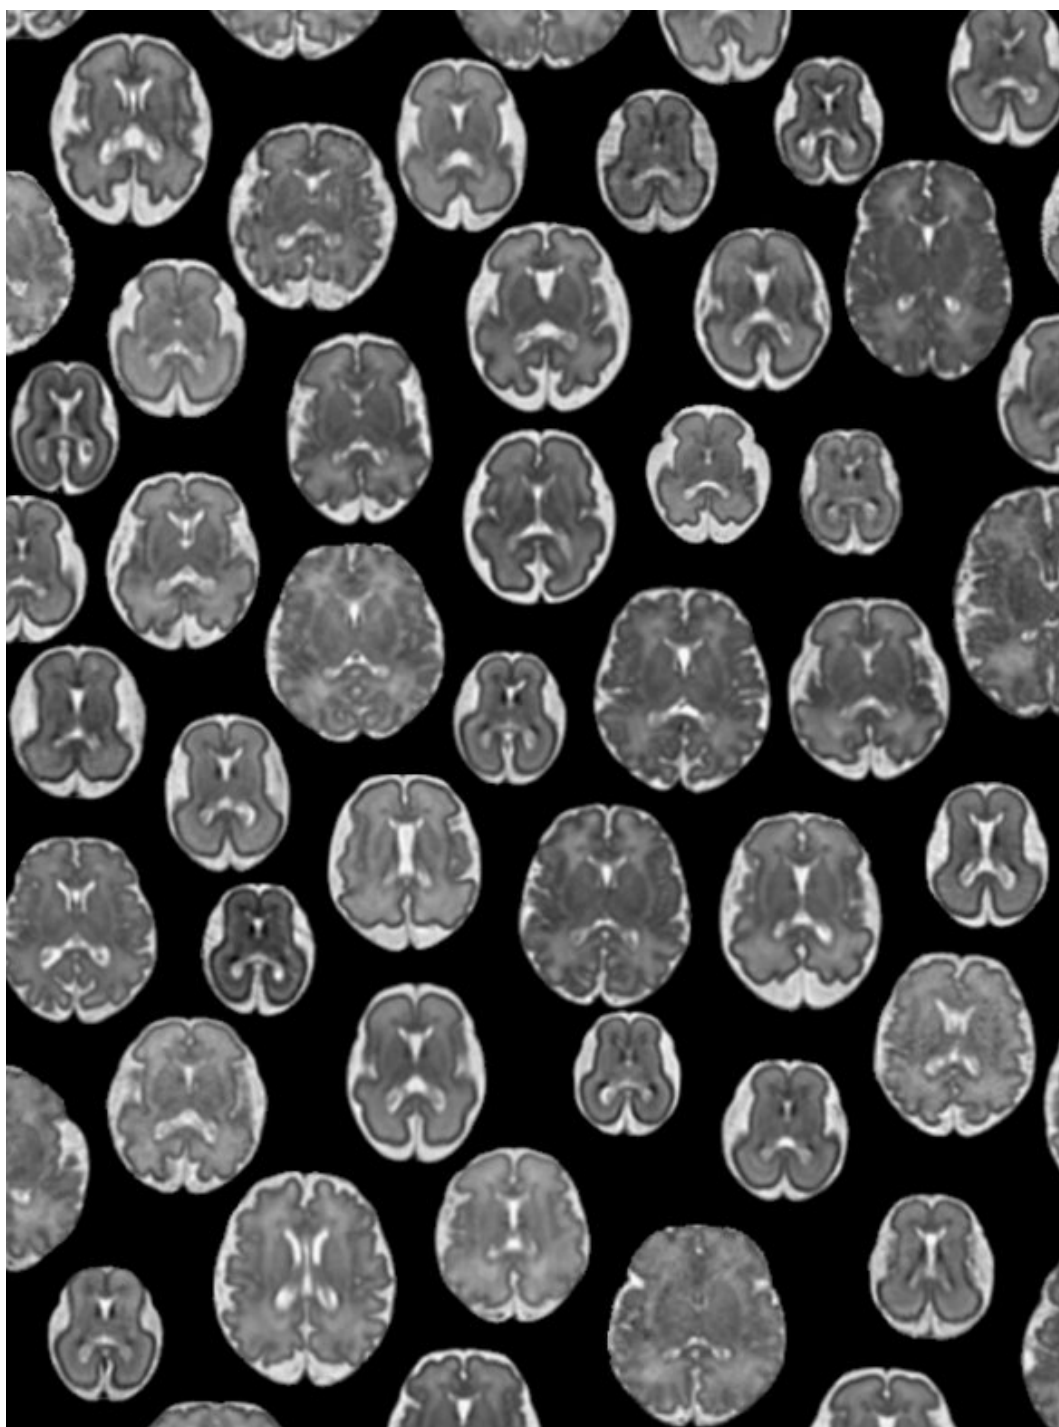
Fetal MRI dataset examples. Axial slices of the fetal brain are shown for random subjects from the fetal dataset used for this thesis (gestational age range: 21.7 – 38.9 weeks).
